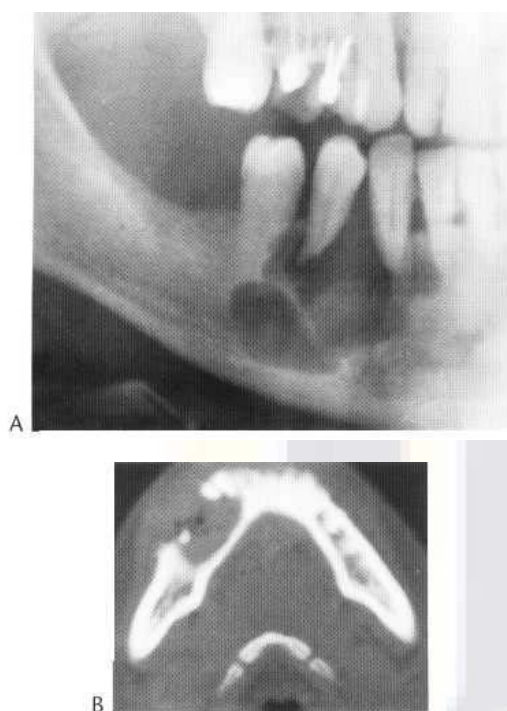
Ameloblastoma. (A) The radiograph shows a well-defined multilocular lesion which characteristically reaches the alveolar margin and erodes teeth. This latter feature is unusual in lesions other than ameloblastoma. (B) The CT scan demonstrates the marked expansion caused by these tumours in the axial plane.
